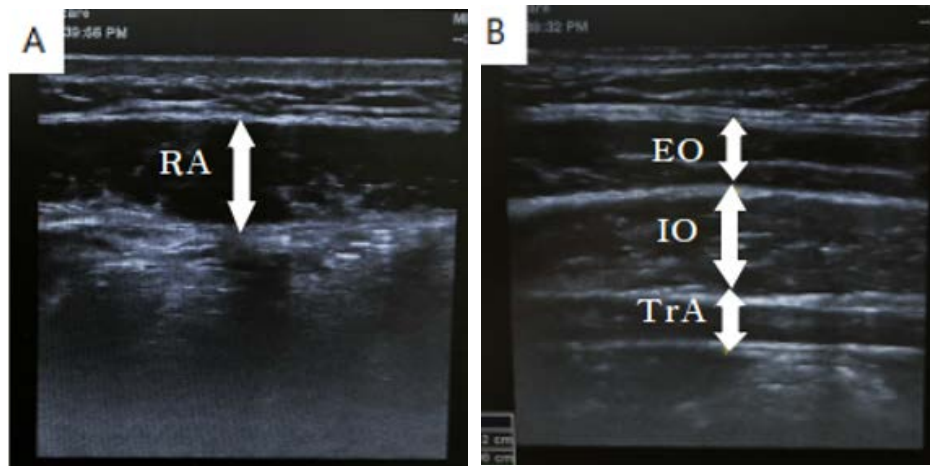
Ultrasonographic images of abdominal muscles. (A) rectus abdominis (RA); (B) external oblique (EO), internal oblique (IO), and transversus abdominis (TrA).
